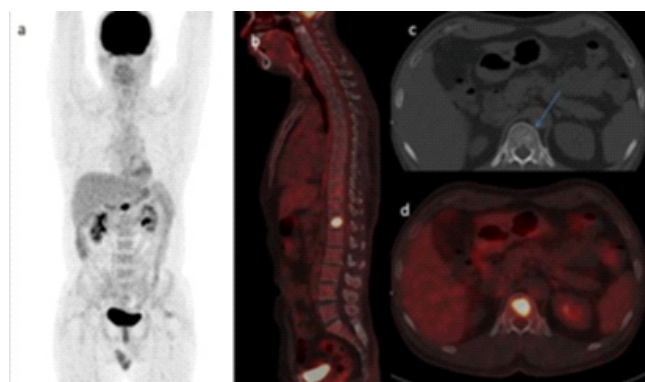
A 54 year old man with suspicion of tonsillar carcinoma. Fluorine-18-FDG PET/CT: unexpected and atypical uptake in T12 vertebra (SUVmax 7.2). Following MRI diagnosed vertebral hemangioma [36].
